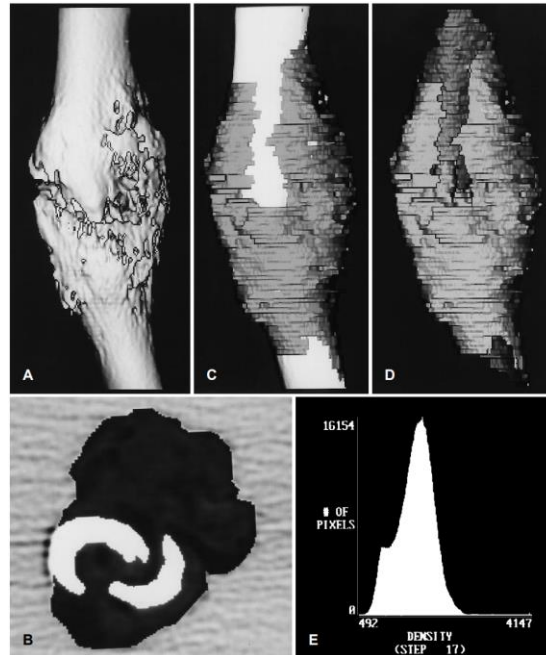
From den Boer et al., this is an example of a 3D reconstruction of a tibial fracture using CT. A) the CT reconstruction in 3D view; B) the center cross-section of the fracture in which the callus has been segmented (black); C and D) the same reconstruction with the callus segmented (gray) with (C) and without (D) the bone. E) the pixel density frequency distribution (adapted from [41]).
